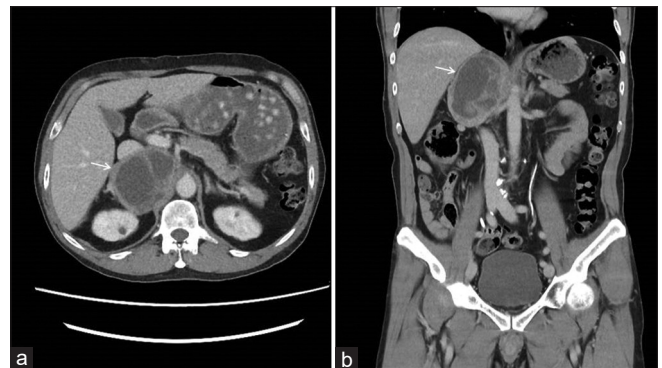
Abdominal computed tomography scan with intravenous contrast, axial view (a) and coronal view (b) showing a well-defined cystic tumor (arrows) with contrast enhancement below the right diaphragm
